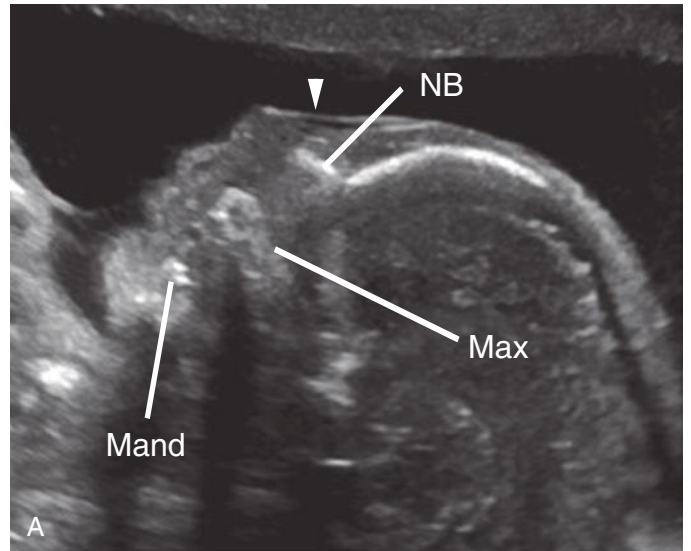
A, Midsagittal view of the fetal face (profile view). B, Axial sonogram through the nose. Note that the cartilaginous nasal septum (arrow) is well seen. Mand, mandible; Max, maxilla; amniotic membrane (arrowhead); NB, nasal bone.
